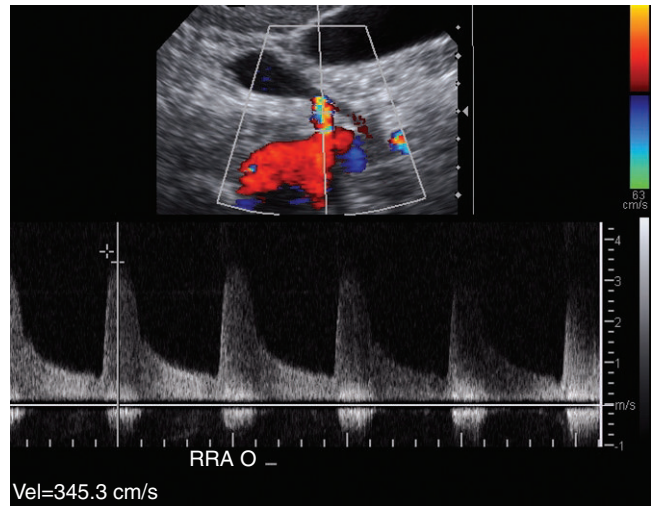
The sonographic image shows an elevated peak systolic velocity (345.3 cm/second – lower left corner) at the origin of the right renal artery.
